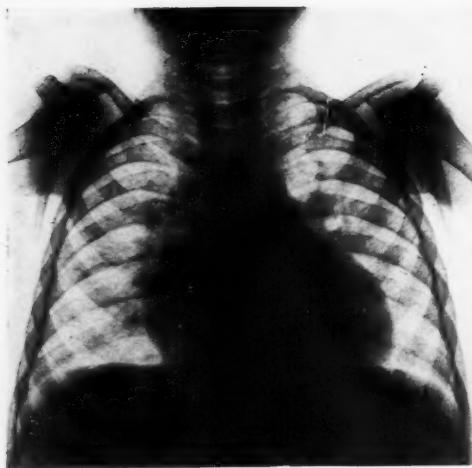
Case 3, aged 4 years. Trabeculations of the ribs, scapulae, and clavicles. These are shown best on the original roentgenogram.
